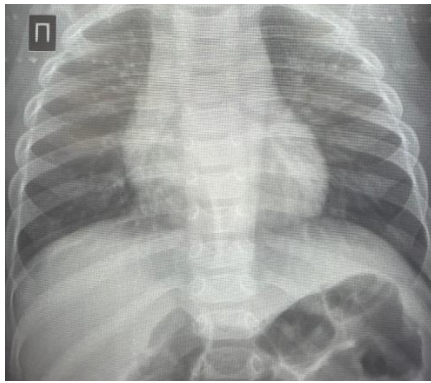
In Patient No. 3, no radiographic evidence of pneumonia was observed on the chest radiograph on day 1 of illness.
